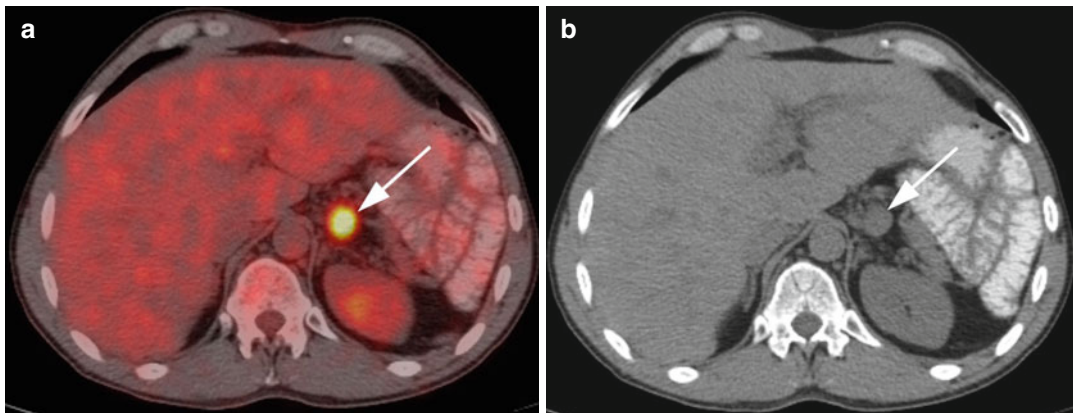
^{18}F -FDG PET/CT in a 45-year-old male with PSC. (a) Markedly PET-avid nonmalignant, reactive gastrohepatic lymph node (*arrow*) depicted by fused PET/
